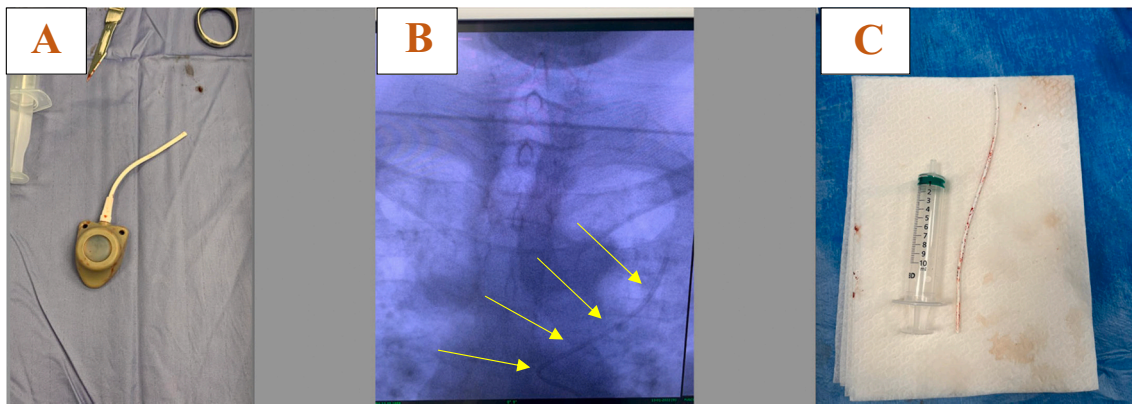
A. Reservoir and catheter fragment connected to reservoir extracted. B. X-ray image obtained in the operating room showing a catheter fragment at the pulmonary artery. C. Fragment of catheter recovered with endovascular procedure, length 19 cm.
